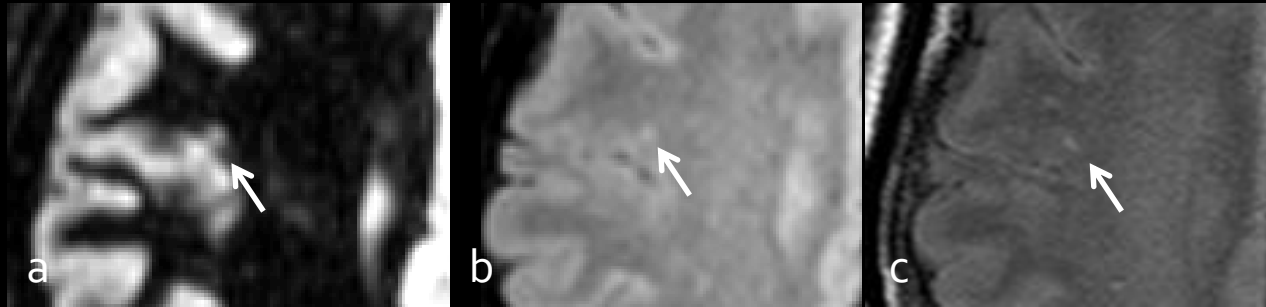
Axial 3D DIR (a), 3D FLAIR (b), and 2D FLAIR (c) demonstrate a hyperintense juxtacortical lesion
